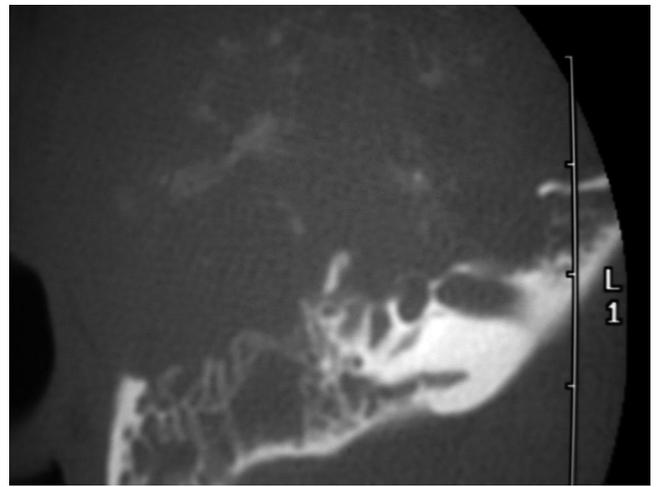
Axial CT shows destruction of the external auditory canal, middle ear, cochlea, geniculate fossa and floor of the middle cranial fossa. Calcifications can be seen dispersed throughout the mass.
